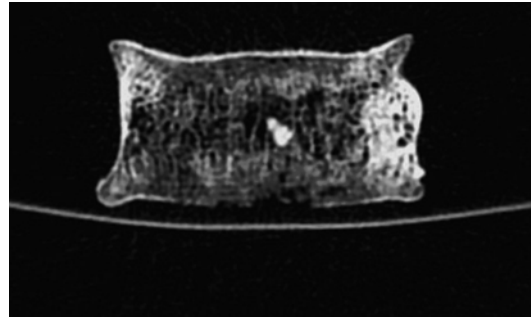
CT scan coronal plane multiplanar reconstruction of the vertebra shows densitometric bilateral peduncular alteration with deformation of the peduncle on the left side
